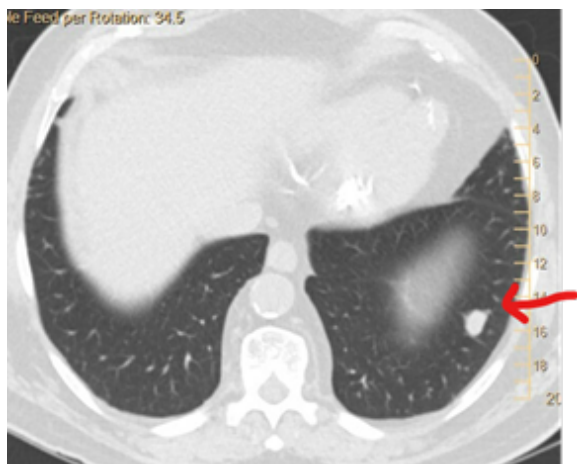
CT Chest Imaging Performed 3 Months after Left Nephrectomy, Highlighting the Largest Nodule in the Left Lower Lung (LLL).
